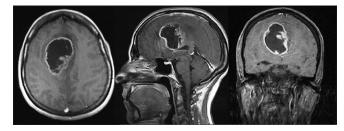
Magnetic resonance imaging with gad on admission, showing a gross frontal glioblastoma multiforme on the right side.
